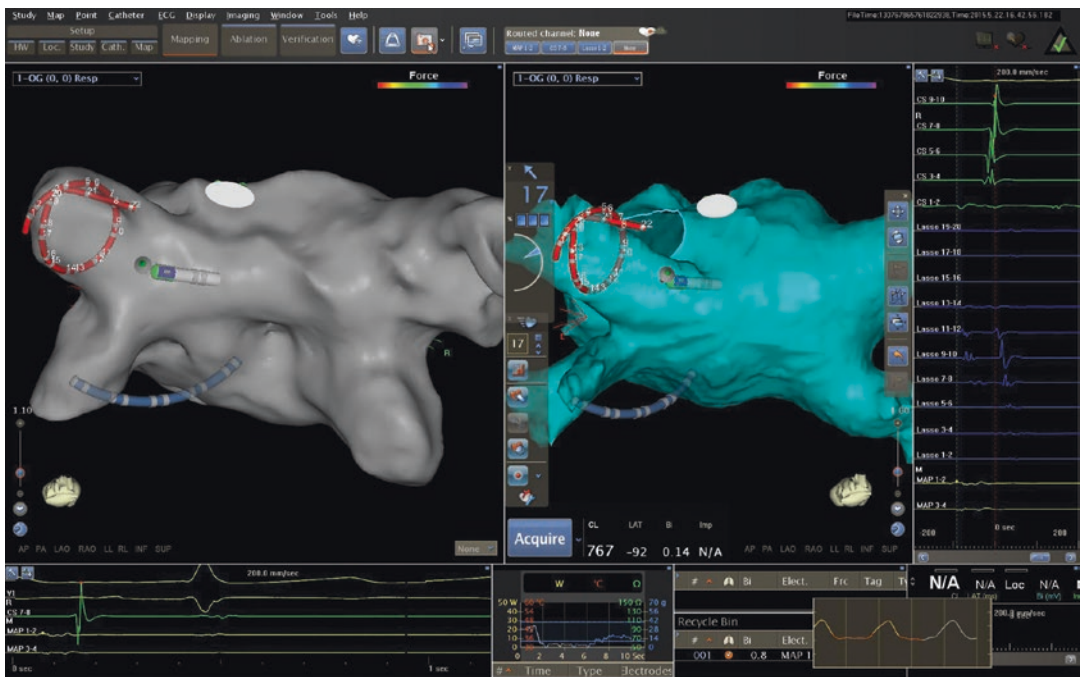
Integration of magnetic resonance imaging (MRI) scan of the left atrium to the anatomic map acquired with Carto3™ (Biosense Webster)
